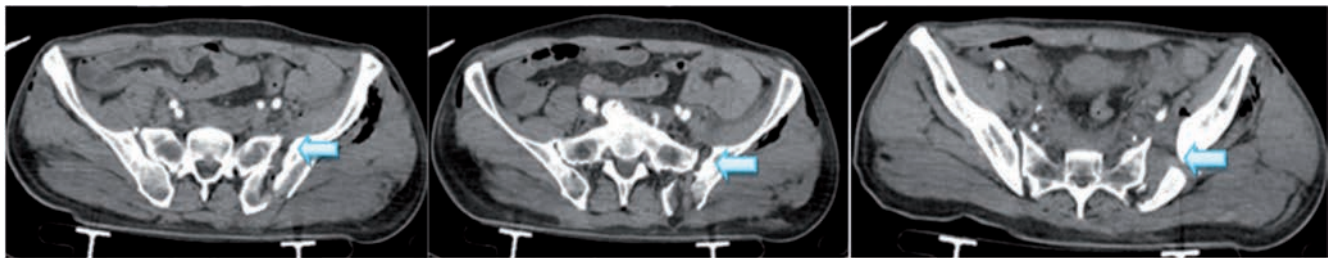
Abdomen computed tomography with IV contrast showing the fracture (blue arrows) and free air.
